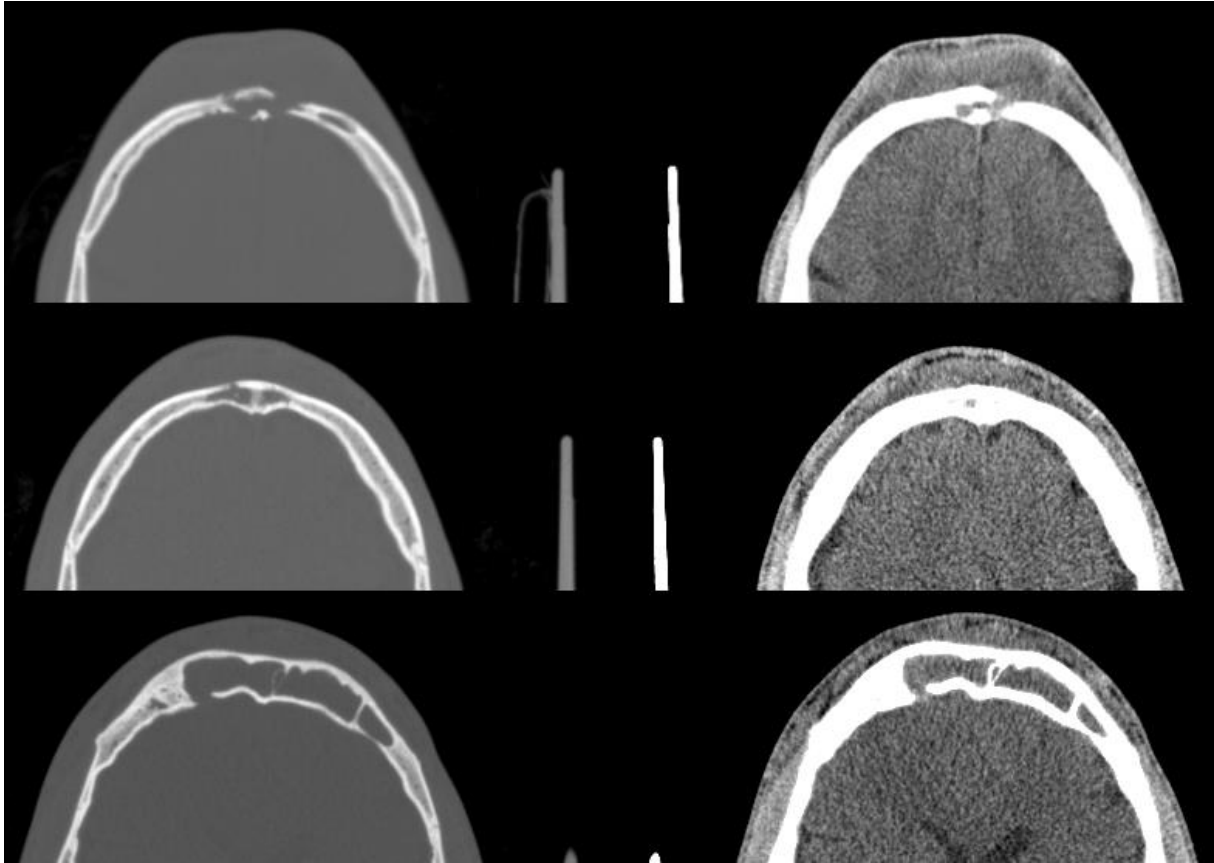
Cranial CT, Transverse section, bone and brain window. There is an abscess that opens under the skin by eroding the frontal sinus anterior wall and opening into the brain by eroding the posterior wall.
